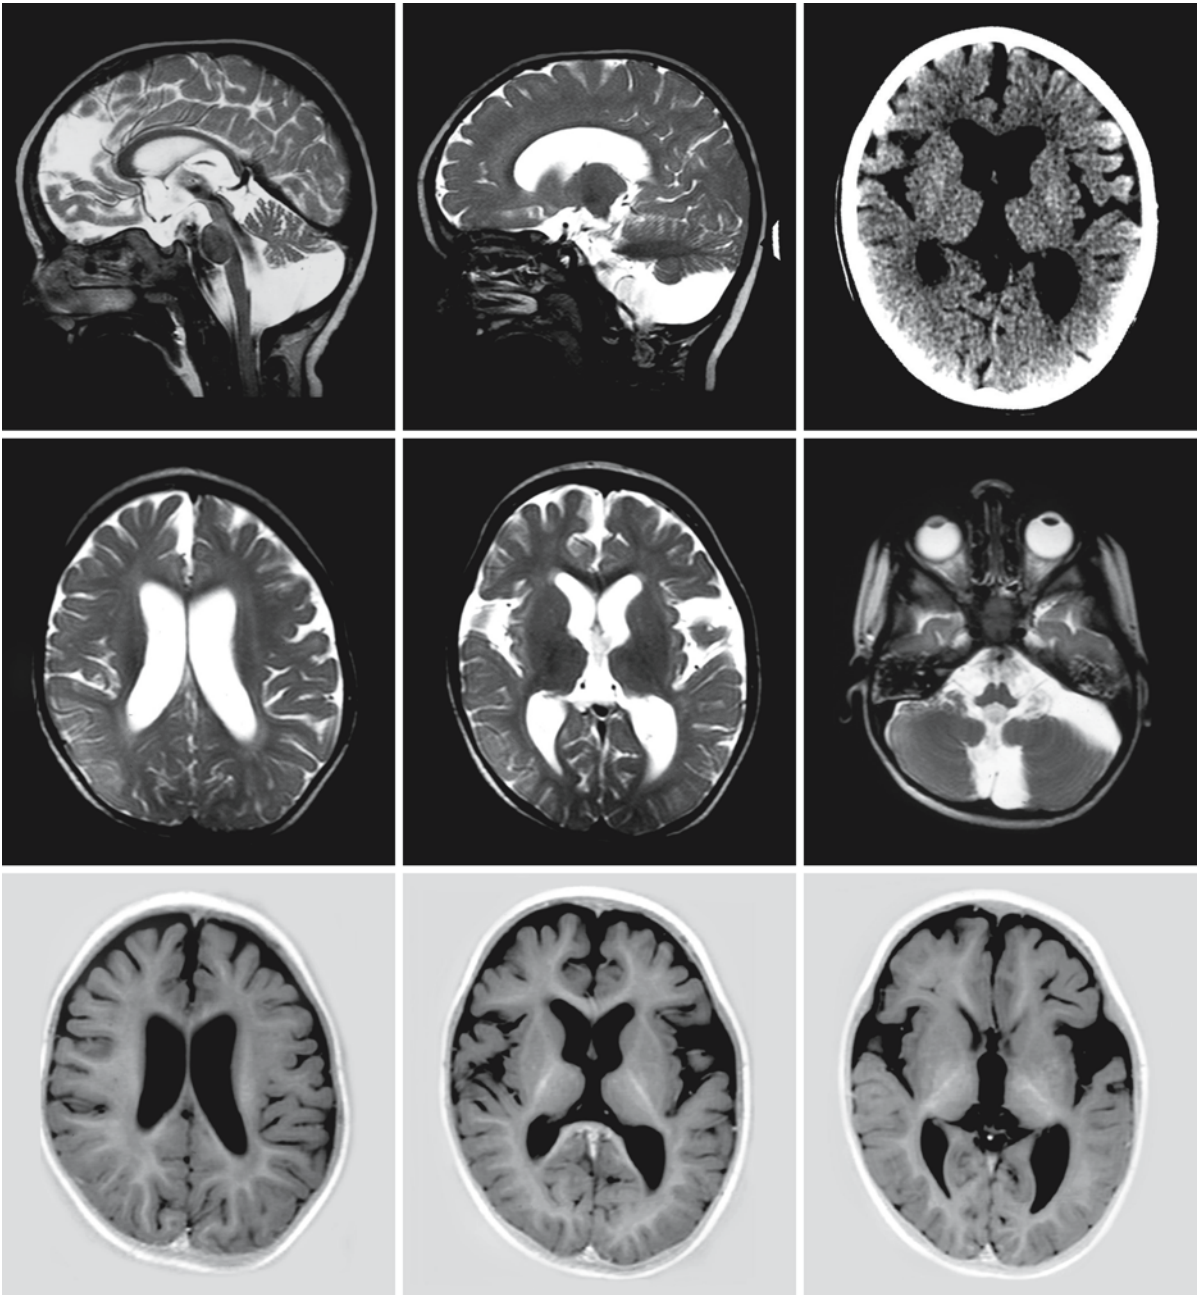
This 3-year-old girl with CS type I has a relatively mild phenotype. The cerebellum is both hypoplastic and atrophic. The brain stem is relatively thin. The CT scan reveals
